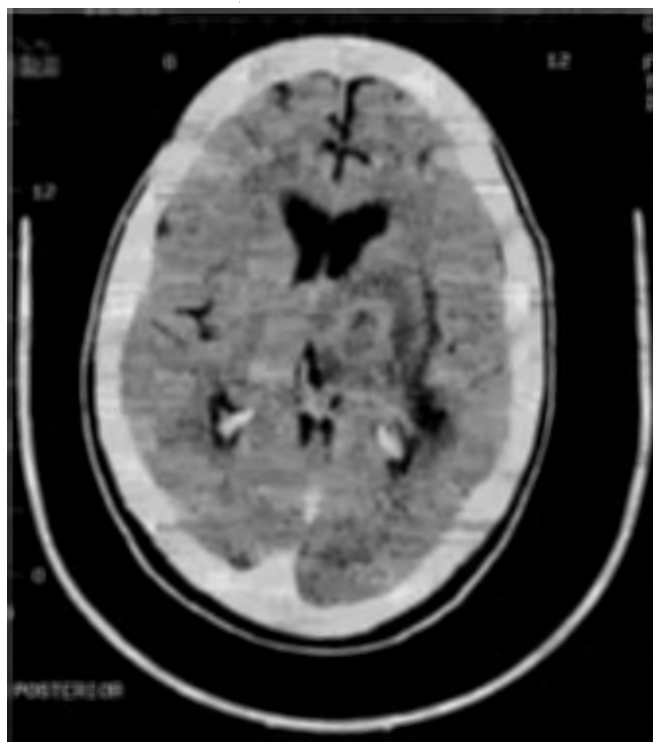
Pre-treatment contrast-enhanced CT scan showing a hypodense lesion in the left basal ganglia with rim enhancement and surrounding oedema, causing effacement of the third ventricle and midline shift.
